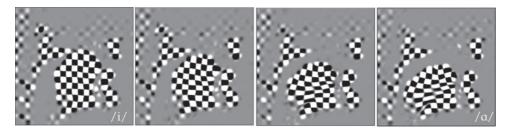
Tagged Cine-MRI sequence shows motion from /i/ to /a/. Checkerboard deformation shows local expansion, compression, and shear.
